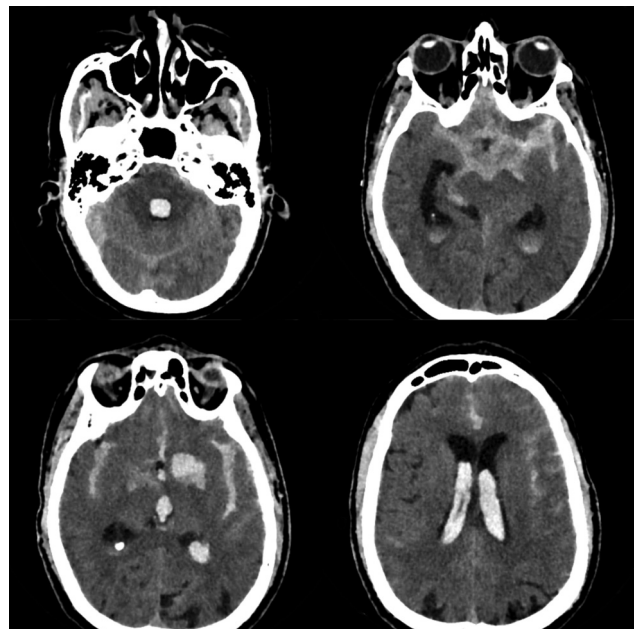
Preoperative plain computed tomography of brain.
